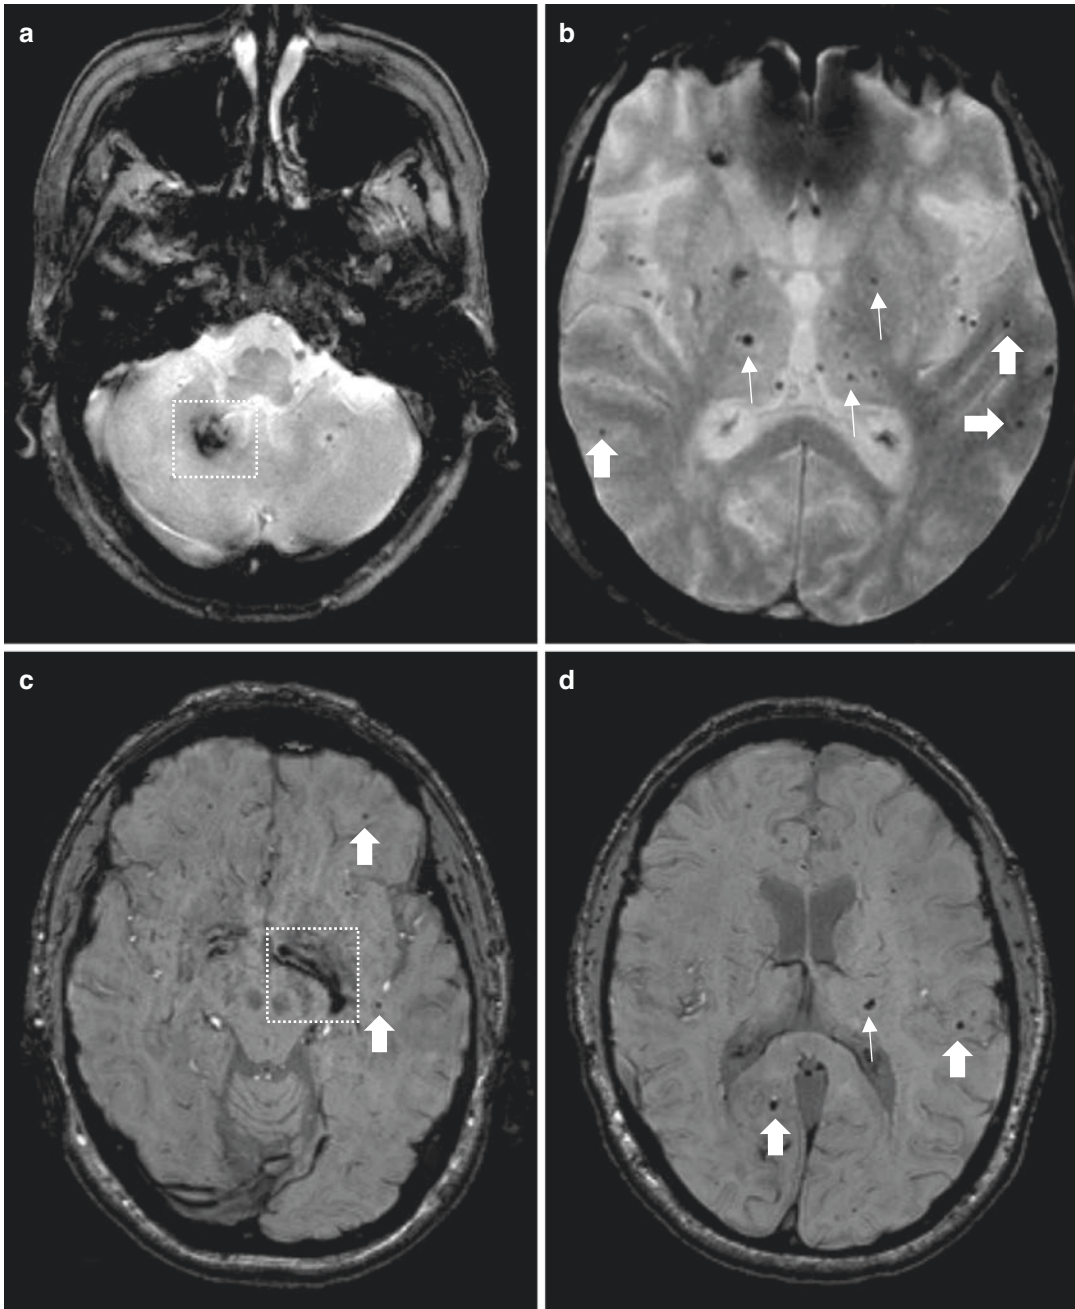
Cerebellar intracerebral hemorrhage and mixed intracerebral hemorrhage. Panels A and B show T2*-gradient echo MRI sequences in a patient with cerebellar hemorrhage. Right deep cerebellar hematoma (a, dotted square box) with mixed distribution of supratentorial cerebral microbleeds (CMB) (b, thick arrows show lobar
